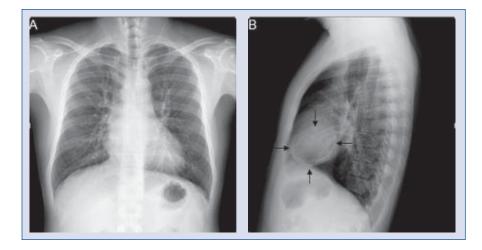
Postero-anterior chest X-ray (A) showed no abnormality. The lateral X-ray (B) showed a calcific pericardiac mass (arrows).
